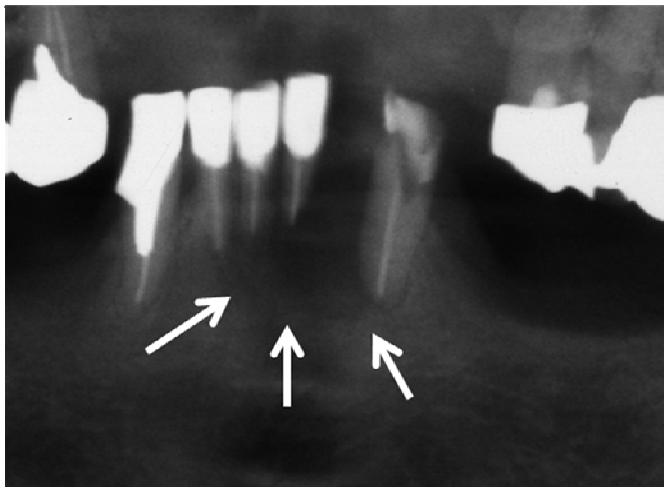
Panoramic X-ray image shows diffuse bone resorption of the alveolar process of the mandible around the apical region of the left lateral incisor.
